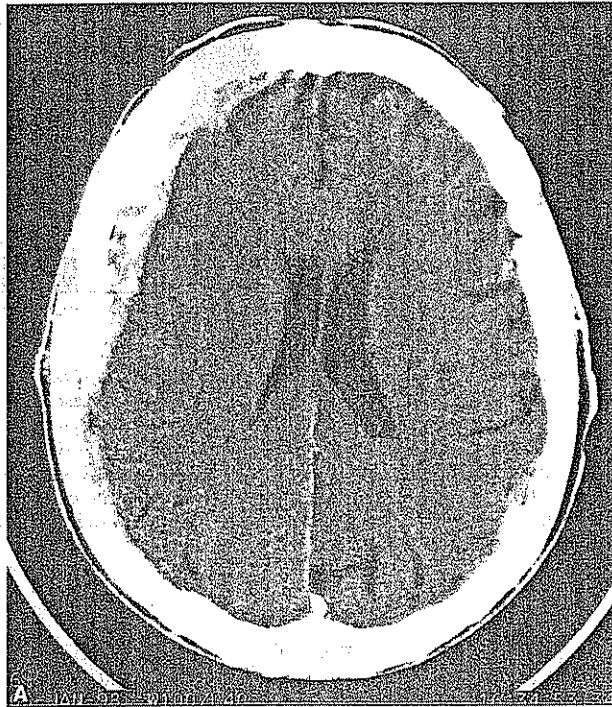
Preoperative brain computed tomography (CT) scan and continuous EEG (CEEG) in patient with acute subdural hematoma (SDH) who suffered postoperative nonconvulsive status epilepticus (NCSE). (A) Extensive right hemisphere acute SDH. Cortical sulci are effaced, and there is mild mass effect. (B) Three days postoperatively, patient is obtunded with no convulsive activity. Prominent periodic lateralized epileptiform discharges (PLEDs) arising from the right hemisphere. (C) PLEDs evolve to focal nonconvulsive seizures (NCS) with spread to left frontal region. NCSE consisted of recurrent cycles of this ictal pattern. (From Jordan 1999, with permission).
